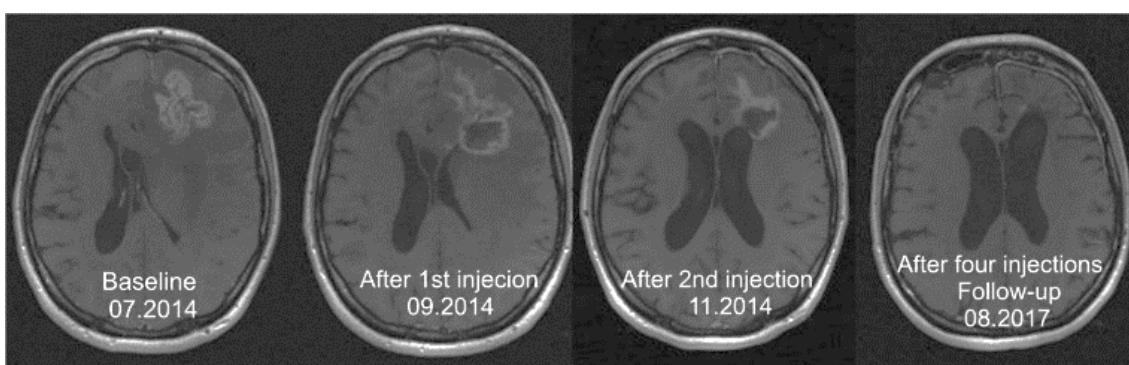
MRI evaluation of a 32-year-old woman suffering from a secondary GBM, following treatment consisting of surgery, radio- and chemotherapy with TMZ and four cycles of [^{213}Bi]Bi-DOTA-SP. Image adapted from reference (163).
